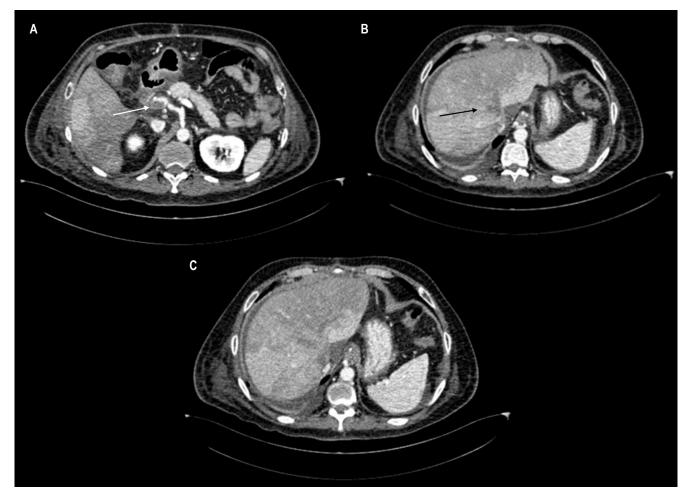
Computerized axial tomography (CT) of the abdomen. A. The axial plane reconstruction shows a thrombus with subtotal obstruction in the portal vein (white arrow). B. Total occlusion in the suprahepatic veins (black arrow), making up the diagnosis of Budd-Chiari syndrome. C. Hepatic areas of heterogeneous enhancement are a characteristic pattern of this syndrome.
